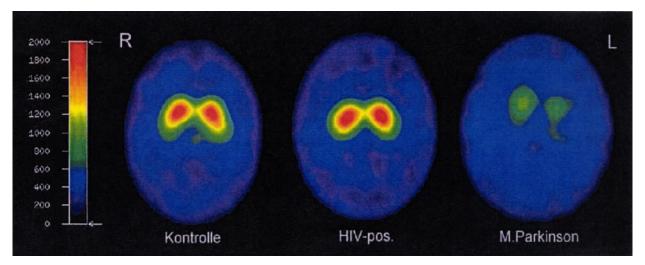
SPECT scan with I-123-FP-CIT visualizing the dopamine transporter in the basal ganglia of a healthy control (*left*), an HIV-1–positive patient (*middle*), and a patient suffering from Parkinson's disease (*right*).
